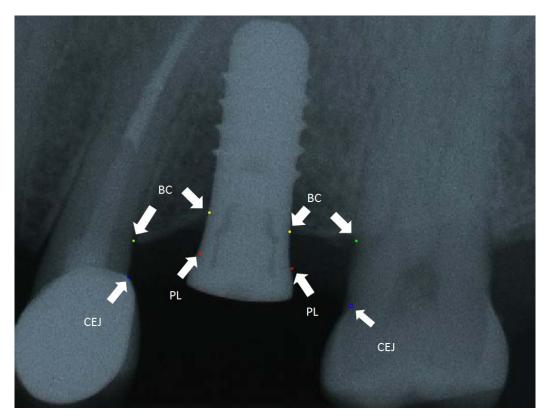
Radiographic reference points used for radiographic mesurements.
